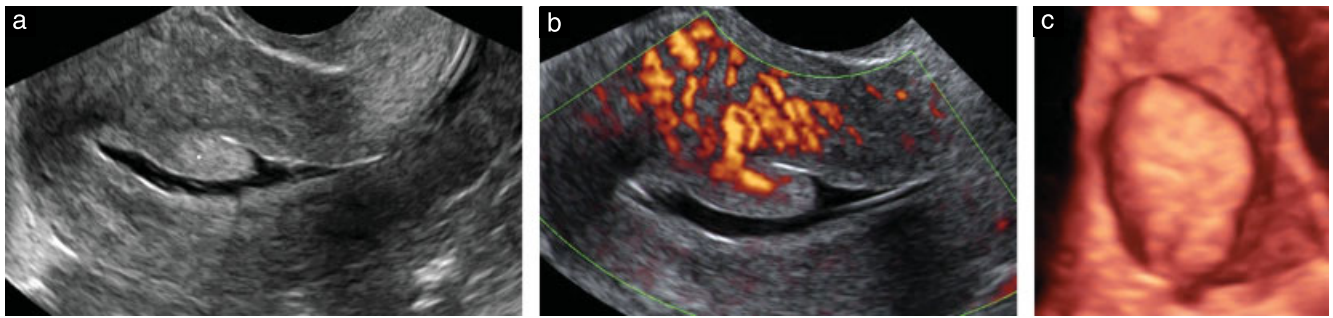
Images obtained on gel infusion sonohysterography showing an endometrial polyp on gray-scale (a), power Doppler (b) and three-dimensional (c) imaging.
